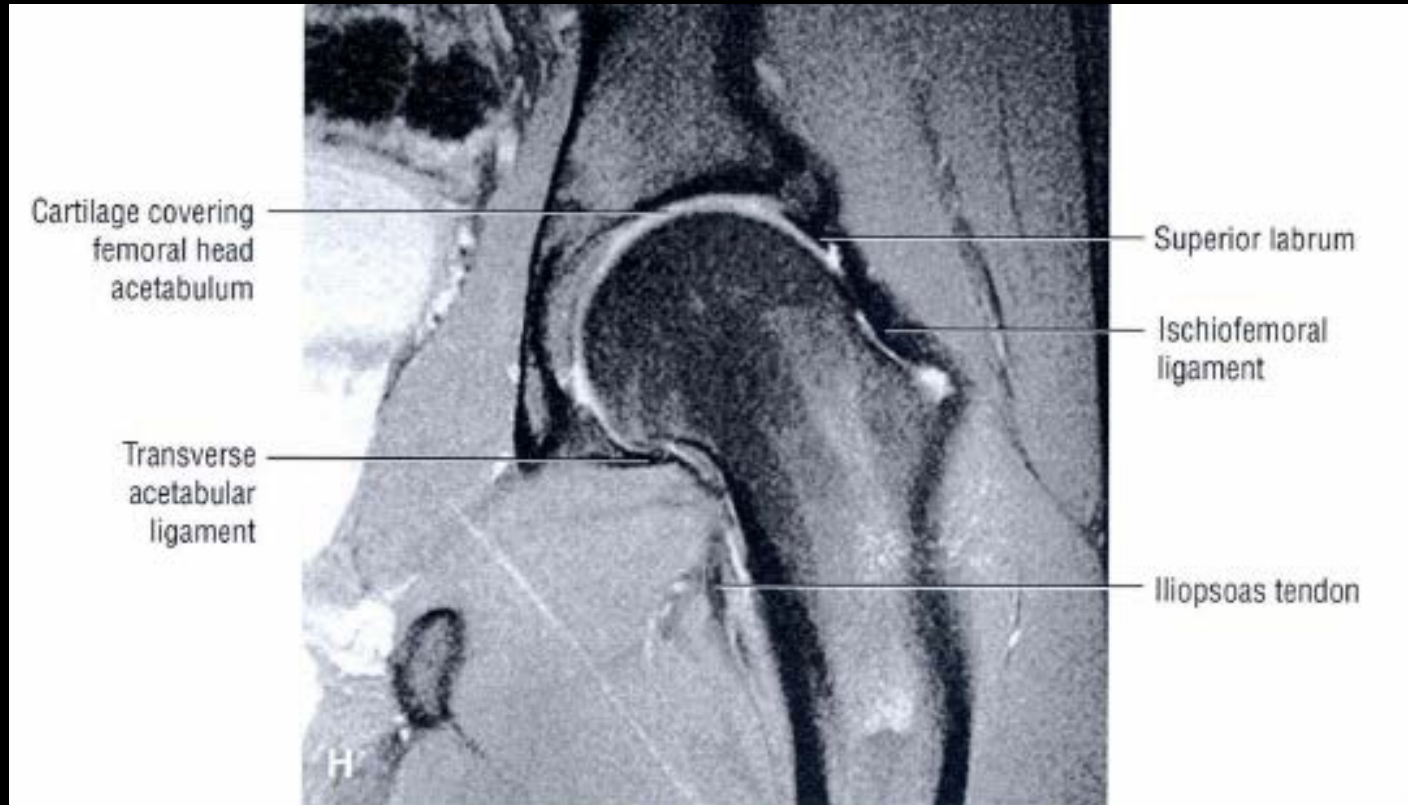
Normal coronal MR anatomy. (A) Sagittal localizer used to graphically prescribe coronal T1-weighted image location from (B) anterior to (L) posterior.
